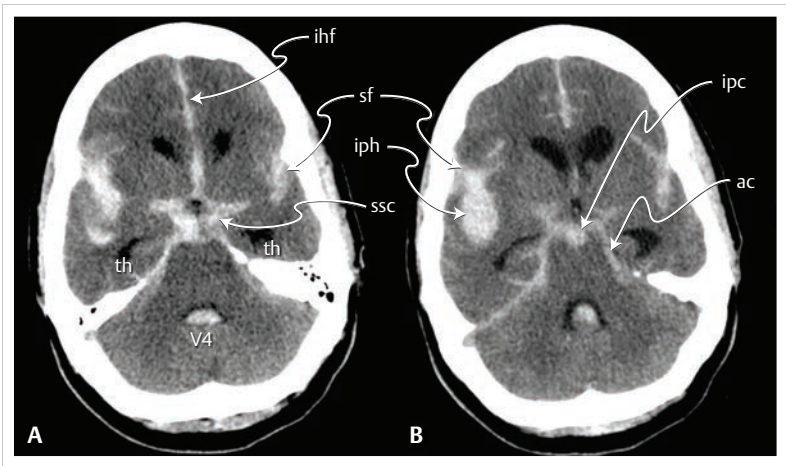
SAH on CT. Image: axial CT scan in patient with SAH (and intraparenchymal hematoma) from a ruptured right middle cerebral artery aneurysm.
